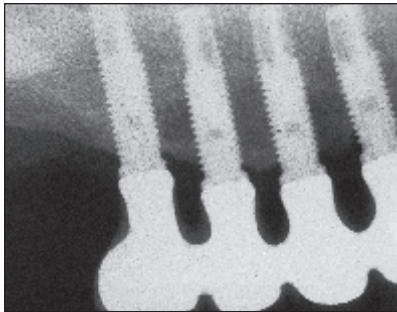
Radiograph of implants after 4 years of loading.
